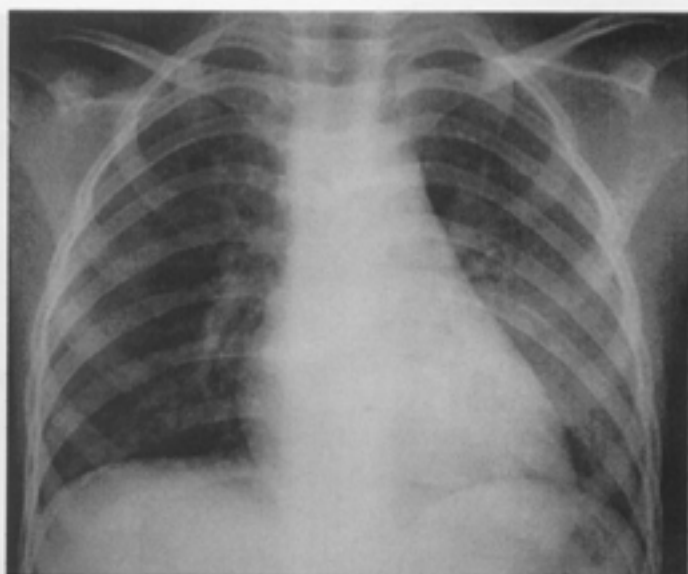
Anteroposterior chest radiograph of a 5-yr-old child showing airspace opacification with ill-defined border in the middle and lower zones of the left lung.
